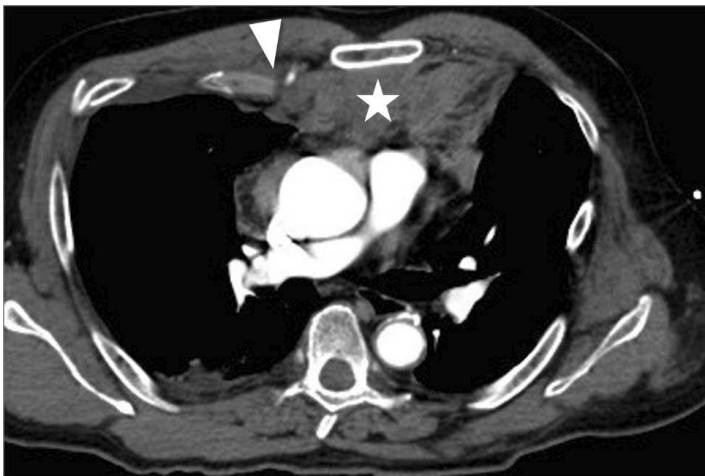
Axial CT image reveals multiple rib fractures and anterior chest wall depression on right. Among other injuries, a posteriorly dislocated costal cartilage fracture (arrow head) and a large retrosternal hematoma (star) are seen.
